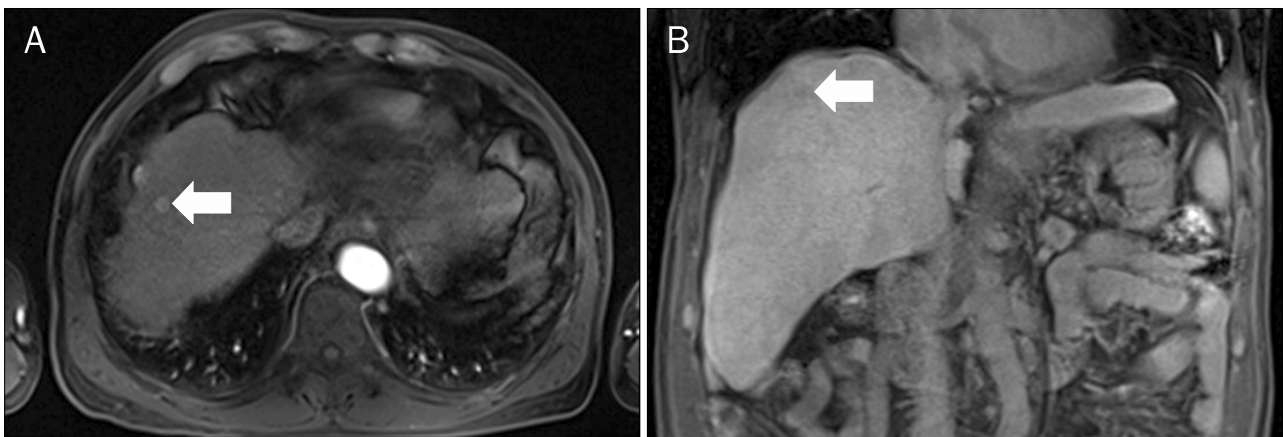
Hepatocellular carcinoma in hepatic dome (segment 8). (A) Axial MRI section showing a slightly enhanced nodule in the hepatic dome (arrow) during the arterial phase. (B) Coronal T1 weighted image showing a hypointense nodule in the hepatic dome (arrow).
